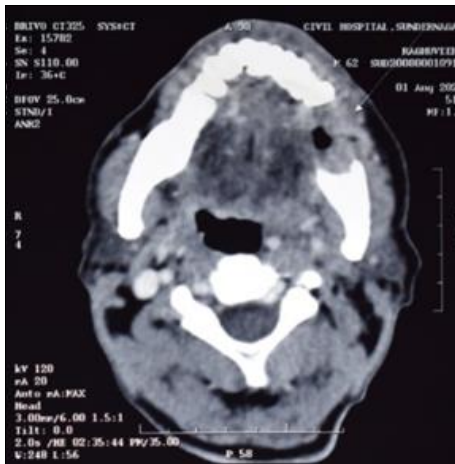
Axial contrast enhanced computed tomography image showing infiltrative soft tissue mass in the left lower alveolus showing destruction of the body of left hemi-mandible
